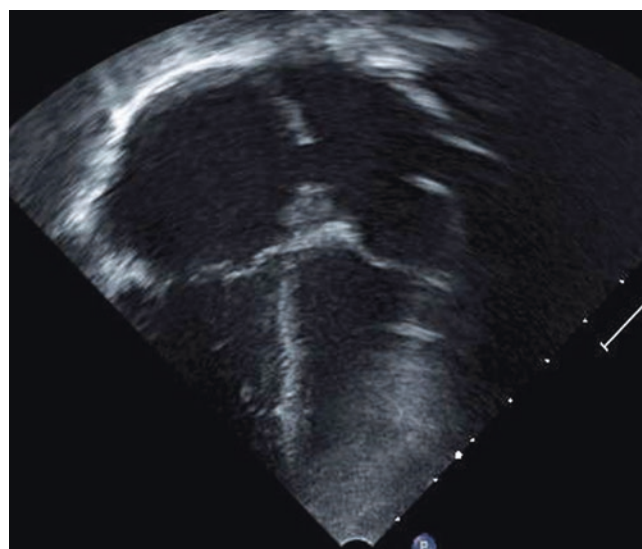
Apical 4-chamber view of a secundum atrial septal defect
